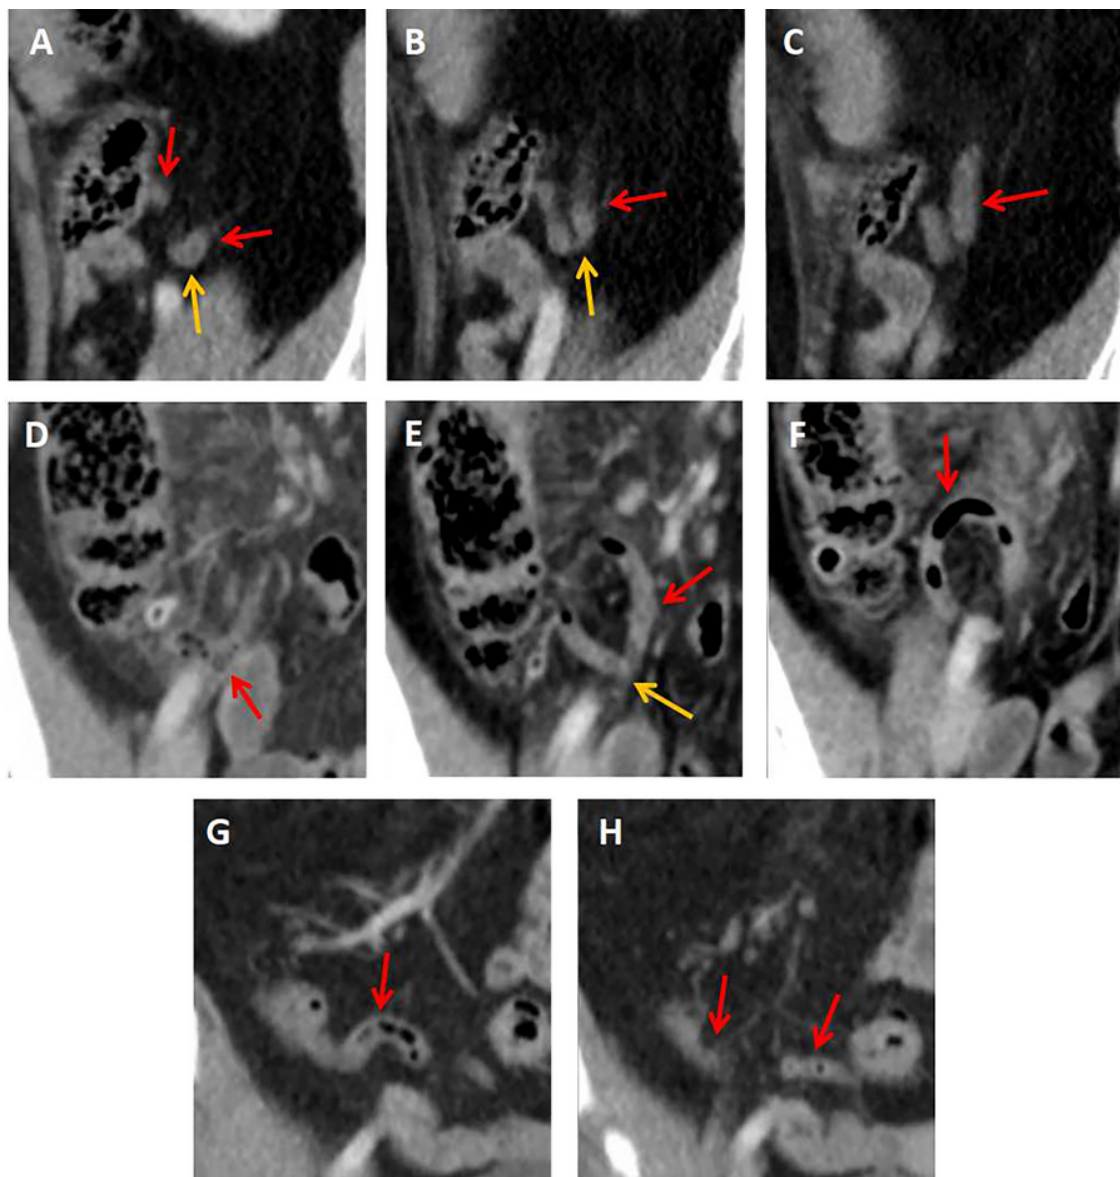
Image appearance of a flaccid appendix: A, B, and C, a 53-year-old male patient with right lower quadrant (RLQ) pain. Post contrast computed tomography (CT) on sagittal view showed a "V shape" appendix (red arrows) distinguished from a "C shape" appendix by an acute angle turn (yellow arrows in A and B). The appendix diameter was 7.8 mm. The patient was diagnosed with right ureterovesicle junction (UVJ) stone. D, E, and F, an "O shape" appendix (red arrows) with mesentery fat stranding in RLQ of abdomen on post contrast CT coronal view in a patient with RLQ pain. The appendix tip "kissing" the opening of the appendix (yellow arrow in E) with a diameter of 7 mm. The patient was diagnosed with ascending colon diverticulitis instead of appendicitis. G and H, a 42-years-old male patient visited our ED due to RLQ pain with final diagnosis of enteritis. Post contrast CT on coronal view showed a bi-curved "S shape" appendix (red arrows). The appendix diameter was 7.2 mm.
